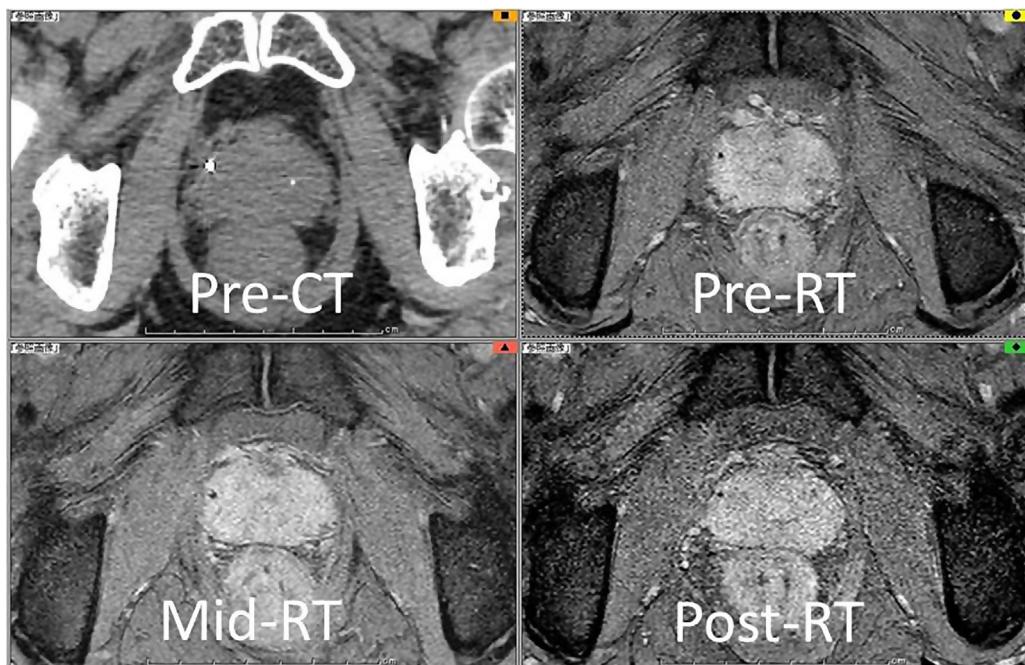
Example of the time course of the prostate volume change. Abbreviations: Pre-CT, pre-radiotherapy computed tomography; Pre-RT, baseline magnetic resonance imaging (MRI); Mid-RT, MRI at the mid-point of the radiotherapy course (about 38 Gy); Post-RT, MRI at the completion of the radiotherapy course.
